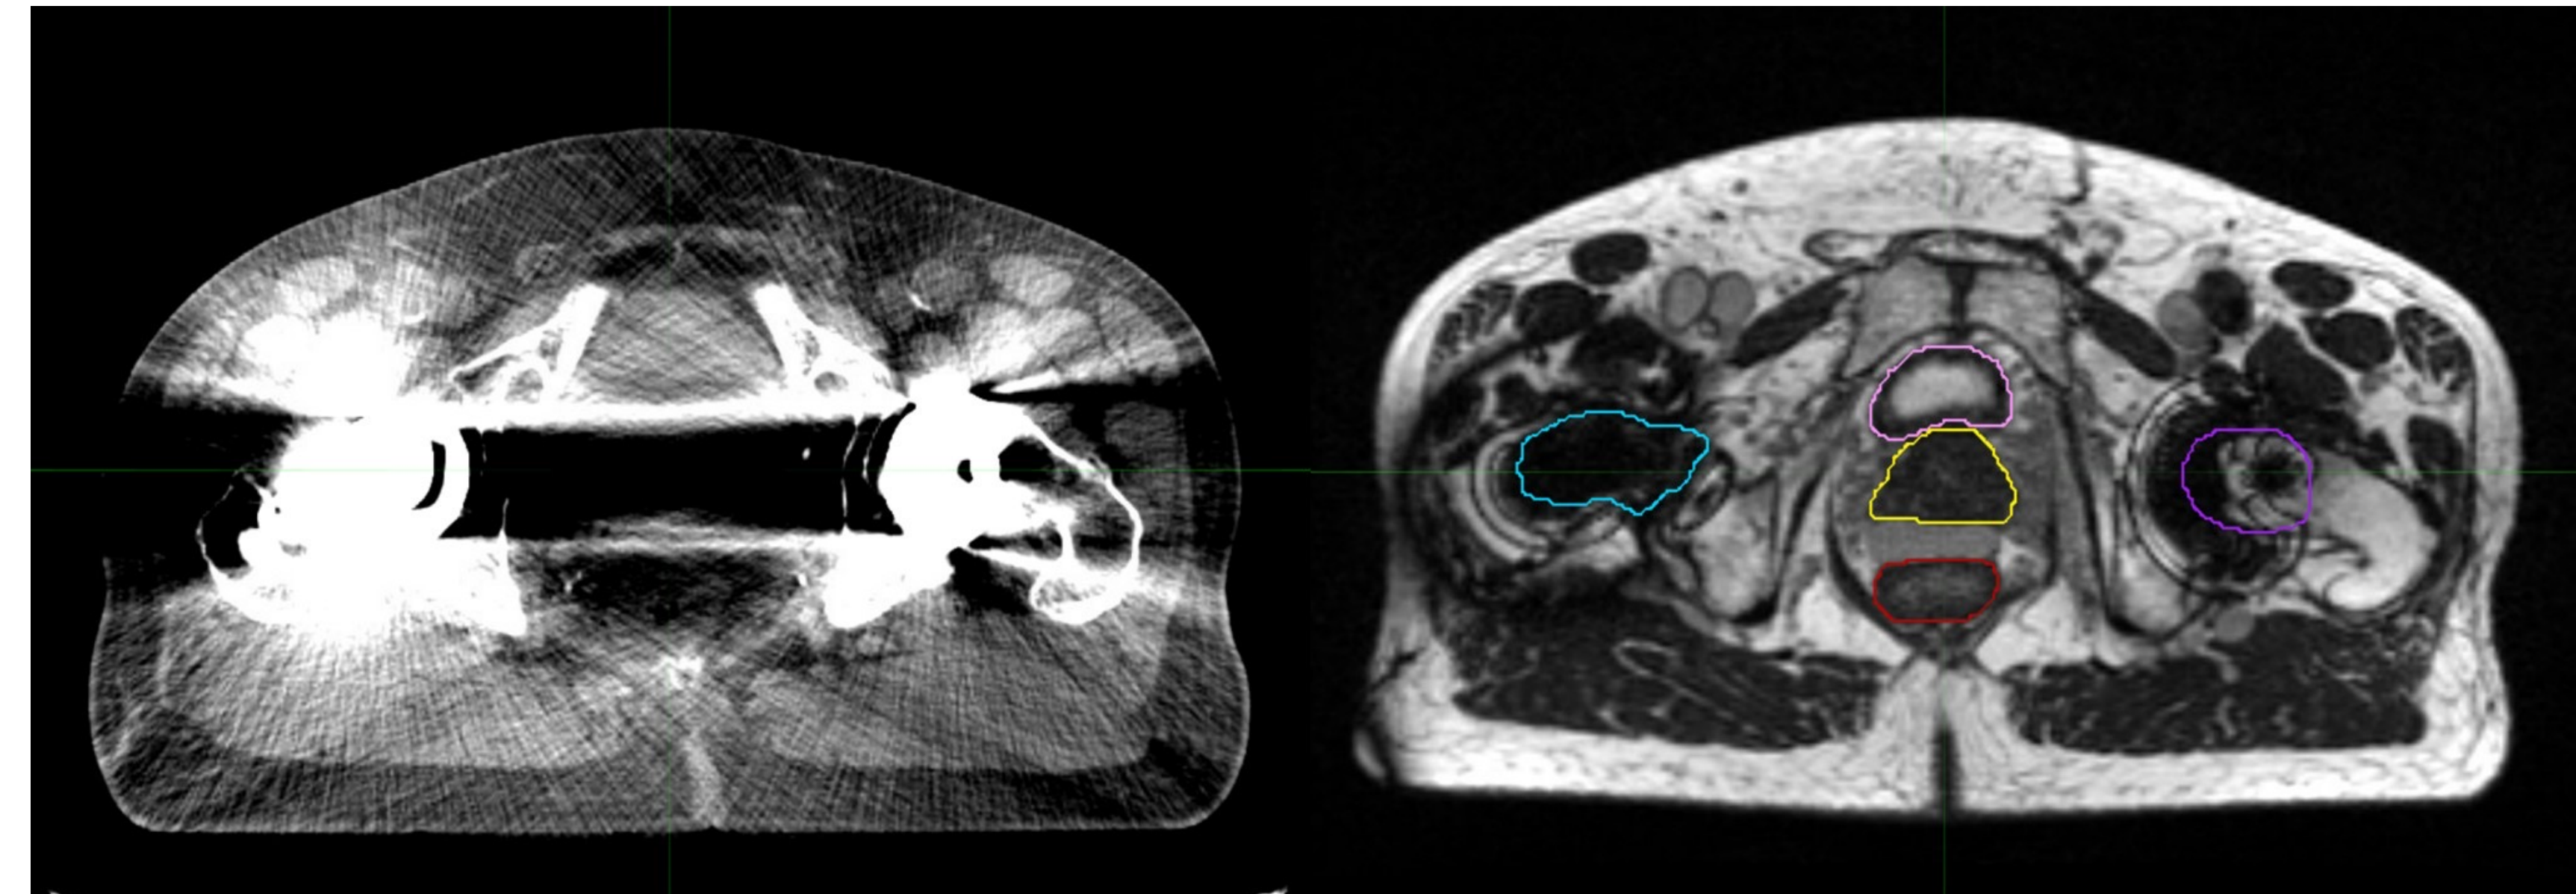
Axial section of prostate and seminal vesicles in patient with bilateral hip prosthesis on planning CT (left) and MR Linac (right)
